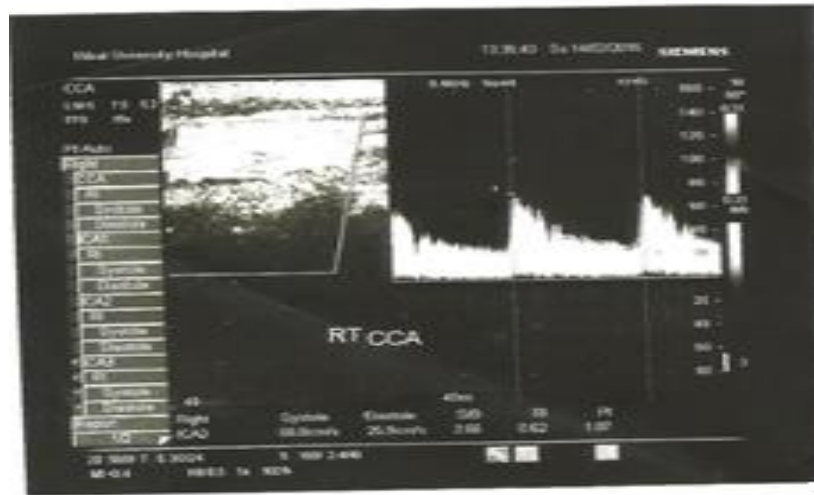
Rt CCA- male- 49 years diabetic patient normal Doppler parameters.
